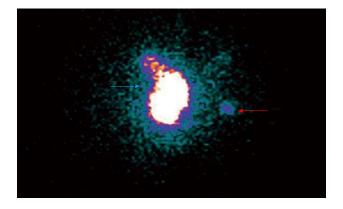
Lymphoscintigraphy of a sentinel lymph node in anal carcinoma. Anterior view showing injection site (blue arrow) and sentinel lymph node (red arrow).
